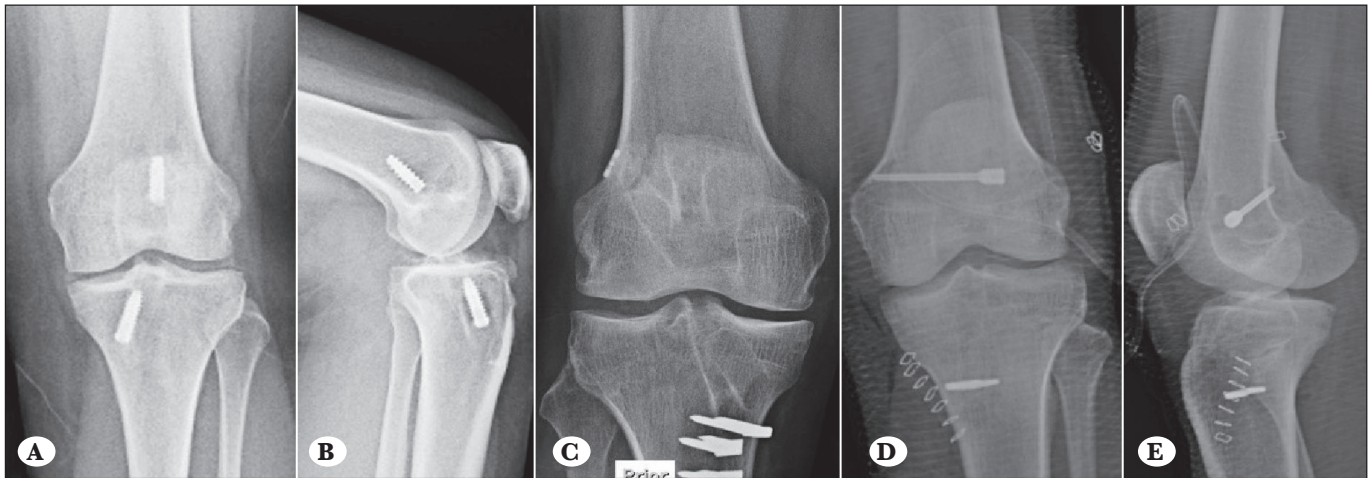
(A, B) A-P and lateral position X-Ray image of the patient’s left knee where a metal interference screw in the femoral and tibial tunnels was used as fixation materials. (C) A-P X-Ray image of the patient where ACL reconstruction surgery was performed for a second time because of ACL graft rupture (direct radiography images showing two tibial tunnels and two femoral tunnels). The graft fixation was done by endobutton in the proximal part of the femoral tunnel and by using staple type of fixation materials in the distal part of the tibial tunnel. In this case, there were also non-metallic interference screws in the tunnels which could not be seen on X-Ray radiography (D, E). Early post operative A-P and lateral position X-Ray images of the patient’s left knee showing that graft fixation was done in the femoral tunnel by using transfix screw, and in the distal part of the tibial tunnel by using staple type of fixation material.
